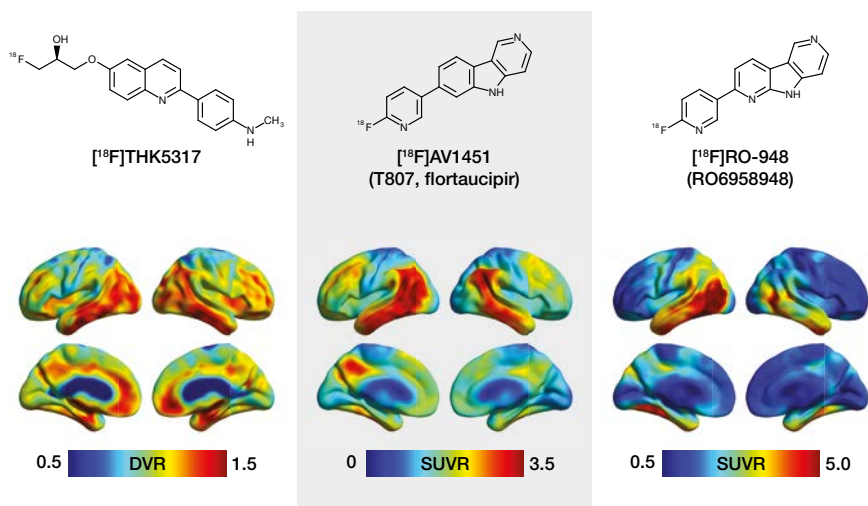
Chemical structures and representative uptake images in amyloid positive AD patients using selected first- and second-generation tau PET tracers. For the creation of parametric images for all tracers, areas of the cerebellar cortex were used as reference. The $[^{18}\text{F}]\text{AV1451}$ image is courtesy of the Alzheimer's Disease Neuroimaging Initiative (ADNI); the $[^{18}\text{F}]\text{RO-948}$ image is courtesy of Professor Oskar Hansson and the Swedish Biomarkers for Identifying Neurodegenerative Disorders Early and Reliably (BioFINDER) 2 study. Though direct comparison is complicated by between-patient differences, one can observe the preferential binding of the first- and second-generation tracers in AD relevant areas of the temporal lobes, and the broader dynamic range seen with $[^{18}\text{F}]\text{RO-948}$. DVR, distribution volume ratio; SUVR, standardised uptake value ratio.
